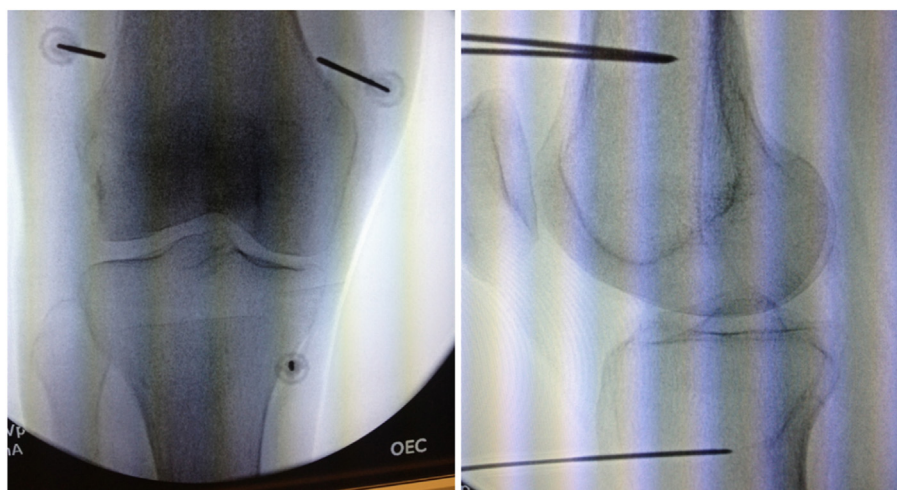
Representative fluoroscopic x-ray images of the locations of introducing needles previous to RF ablation of the genicular nerves of the knee. Left: AP view; Right: Lateral view.
